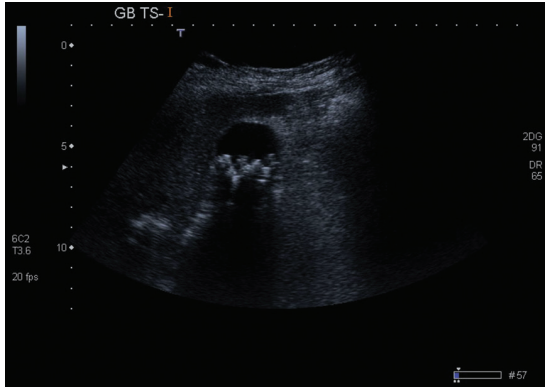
Ultrasound a gallbladder.
